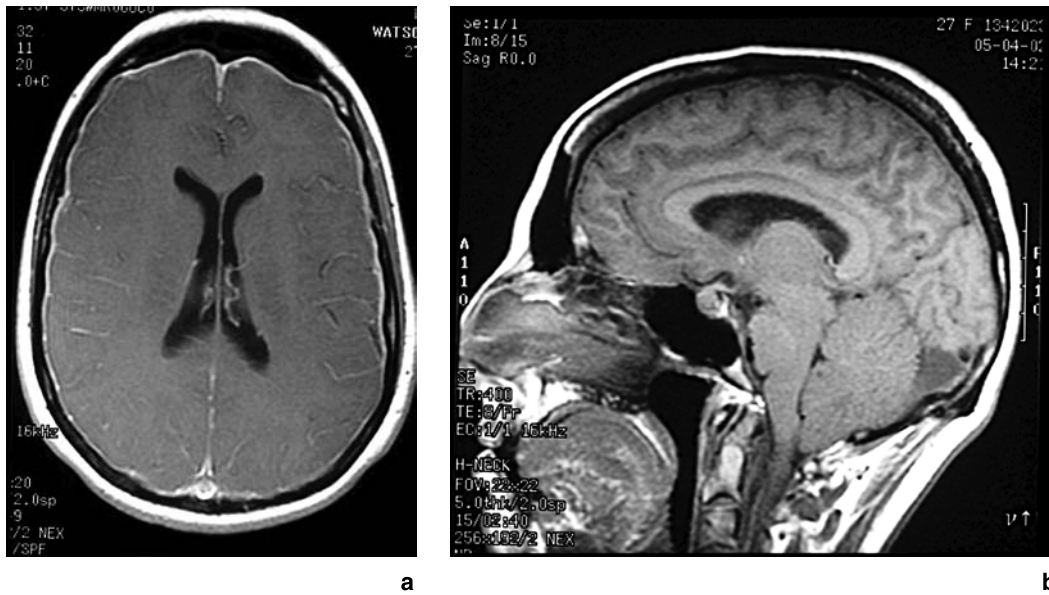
(a) T1-weighted axial MR image with gadolinium demonstrating meningeal enhancement consistent with intracranial hypotension. (b) T1-weighted sagittal MR image demonstrating the secondary Chiari I malformation in a patient with Marfan's syndrome and spontaneous CSF leakage. (c) T2-weighted sagittal MR image showing the extensive cervico-thoracic syrinx
